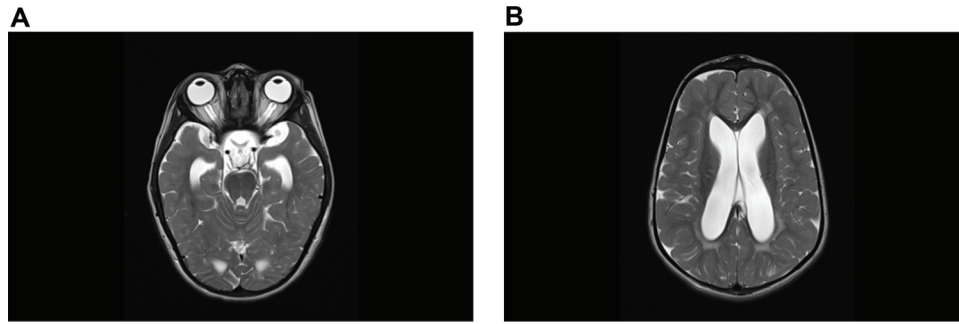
Magnetic Resonance Imaging of Patient with Hemifacial Spasm and Mucopolysaccharidosis Type VI. Axial T2 images demonstrating (A) increased cerebrospinal fluid space around the optic nerves and (B) ventricular enlargement.
